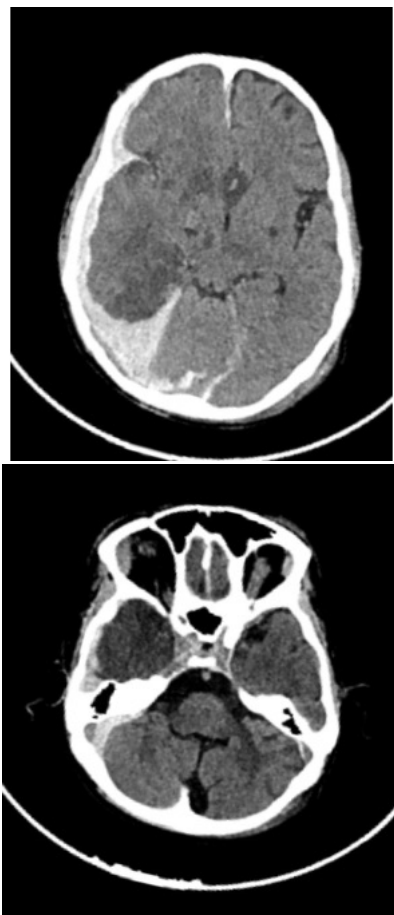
A 14-yr old male patient who fall from height undergone head trauma and have symptoms like severe headache, altered mental status and nausea undergone non contrast CT scan of brain which showed findings like SDH in right frontal, parietal and temporal lobe and SAH in falx cerebri and falx tentorium.
